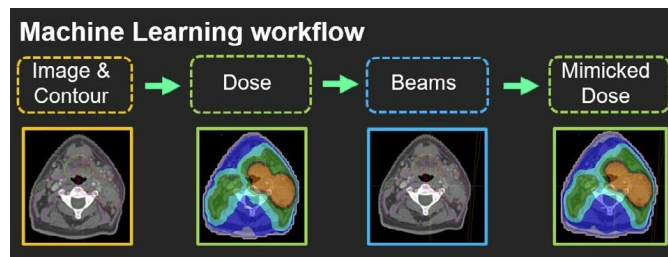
Machine learning process from RaySearch Laboratories. Based on the annotated CT scan of the patient, a model predicts the optimal dose distribution. Then, by dose mimicking, the beam parameters are optimised to reproduce the predicted dose distribution as closely as possible. The distribution dose with the determined parameters is calculated, and the treatment can start.[24]
